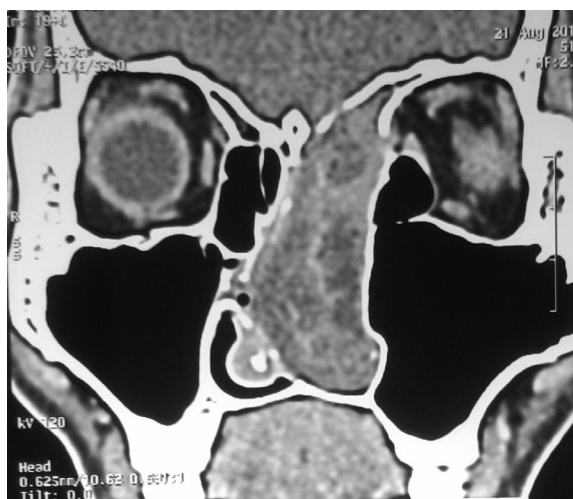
CT scan of the nose and paranasal sinuses showing a soft tissue mass inside the left nasal cavity without any evidence of bony erosion of surrounding wall.
